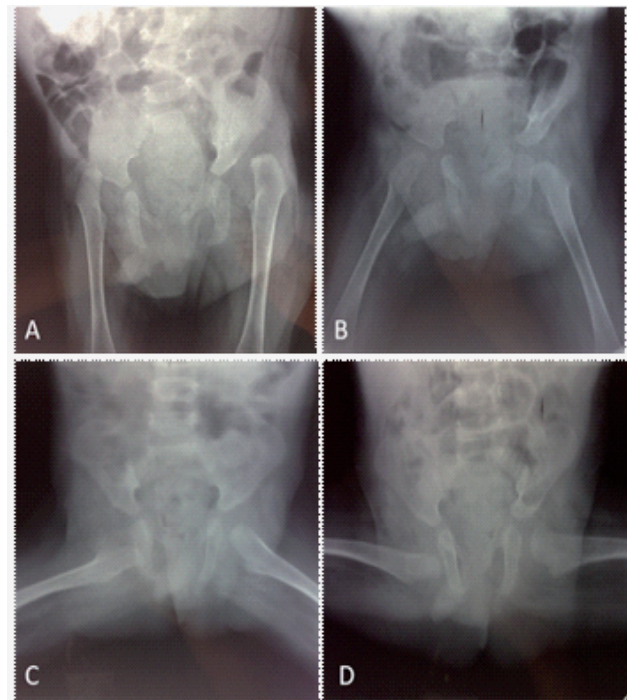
Radiographic examination before (A) and one week (B) after the bracing treatment; radiographic control at one month (C) and three months (D) from the brace discharge.
